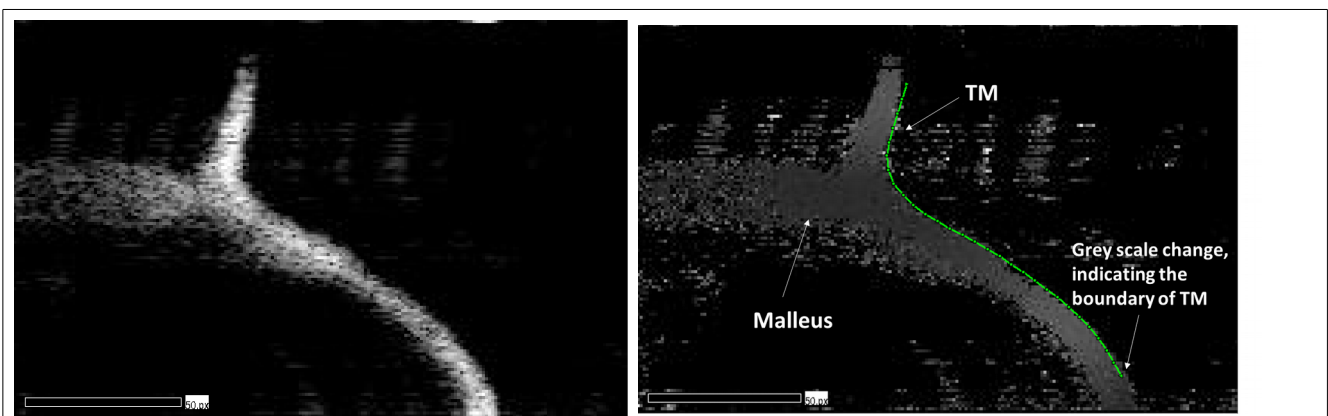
B-mode image with middle-ear structures (left) and Doppler-mode image of the same cross-section. The intensity contrast between the structure in motion (TM), the less-moving structures (ossicles) and the non-moving temporal bone can be identified from the Doppler-mode image.
